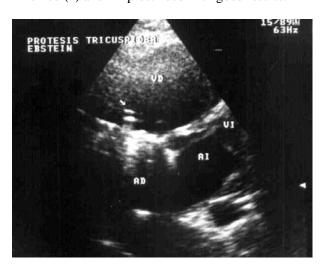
Trans-thoracic echocardiogram, in the same tricuspid prosthesis where you can see that thrombus has disappeared and normal functioning of the mechanical prosthesis 72 hours after thrombolysis.
